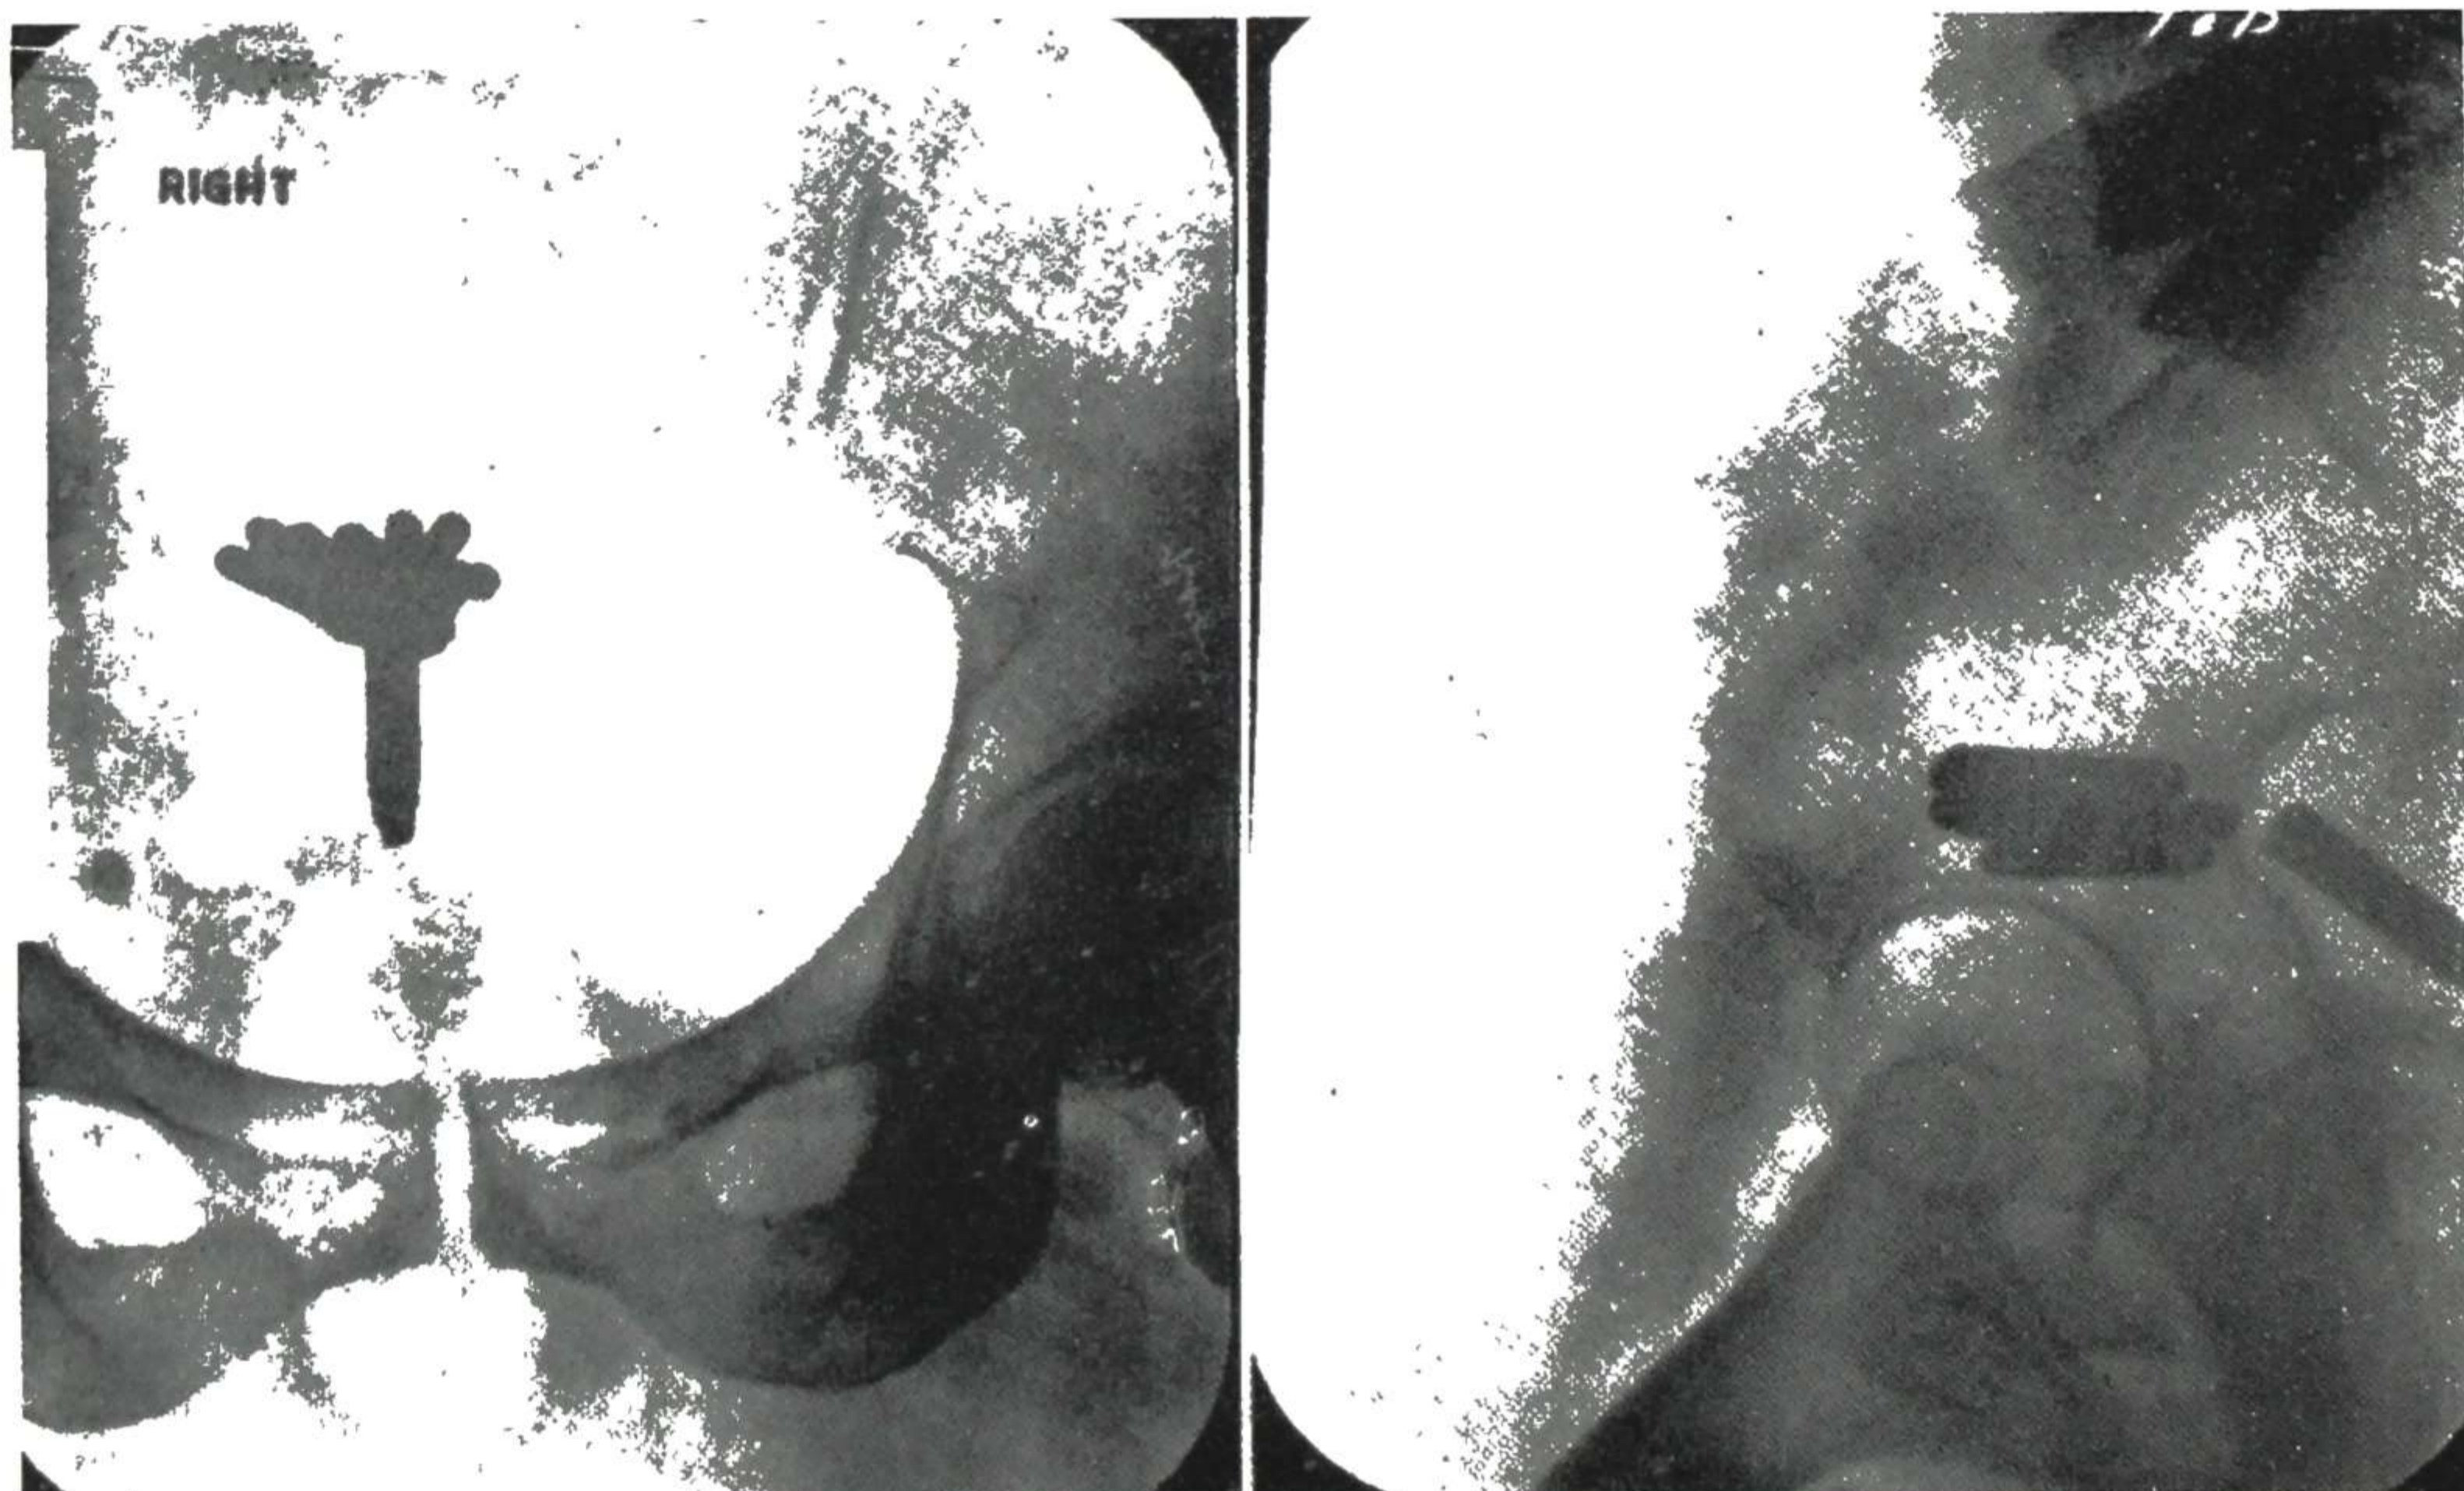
Multiple sources of radium within a uterus somewhat larger than average. A capsule of greater external diameter is located in the cervix. By that means the canal is kept dilated for safe removal of the deeper tubes. The source in the cervix is of greater radium strength than those in the upper part of the uterus. (From Nolan and Arneson: *Am. J. Roentgenol.*, April, 1943.)
